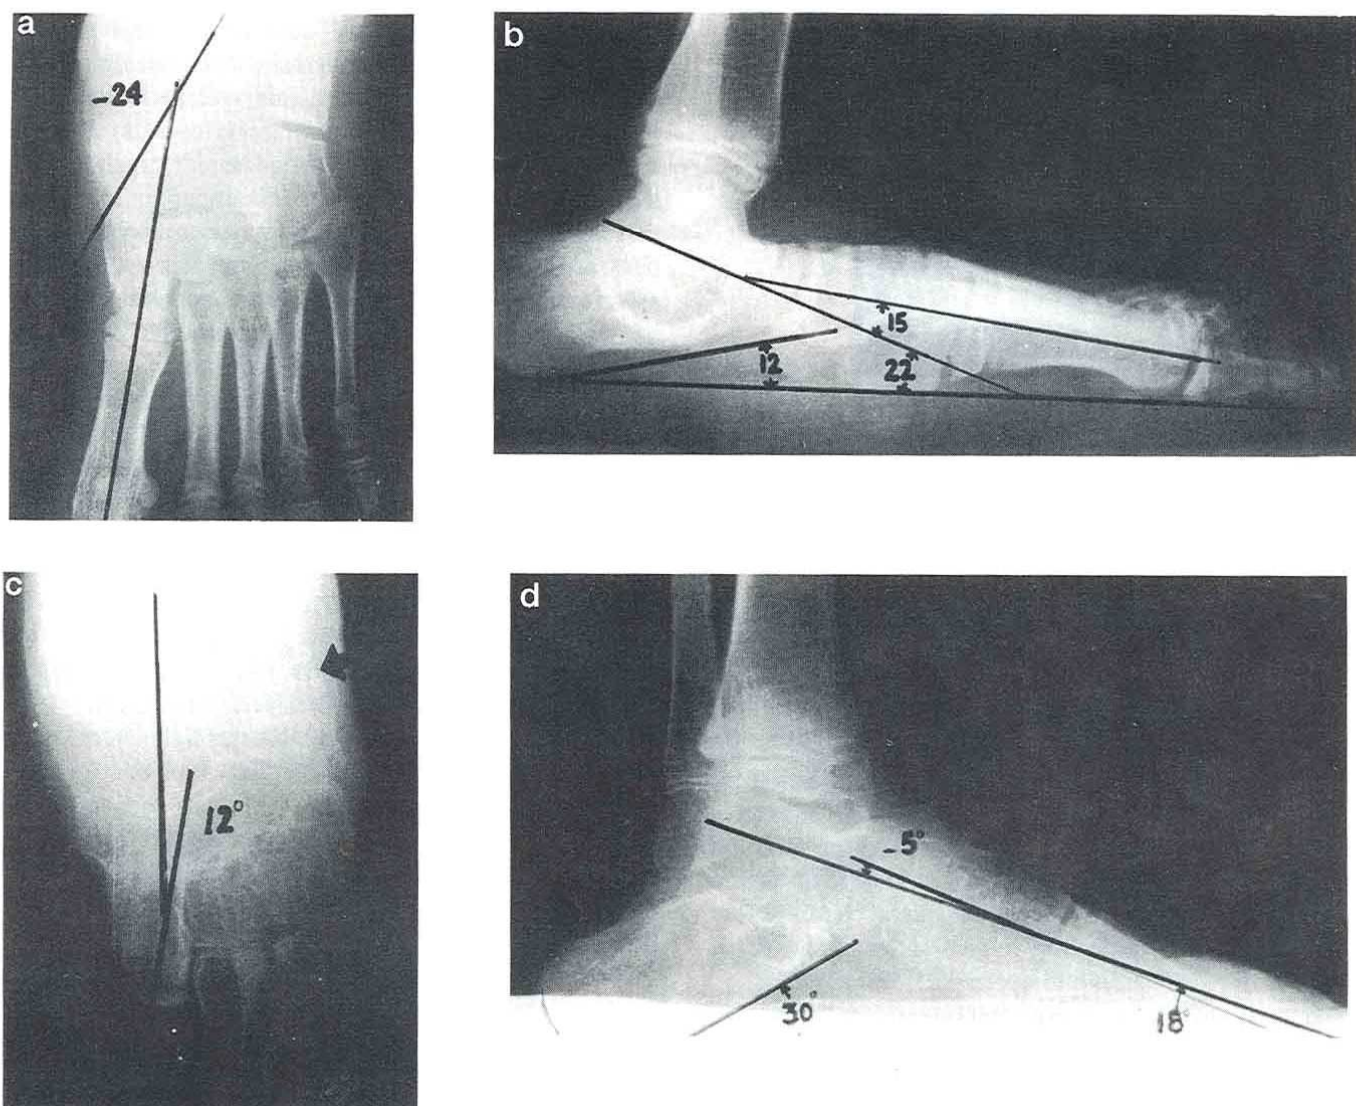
Improvement in radiological measurements. *a* and *b*, Preoperative standing radiographs with evidence of a resorbed iliac graft at site of an old Evans calcaneal osteotomy (case 4, left foot). The arch is flattened with naviculo-cuneiform sag and plantarflexed talus. *c* and *d*, Postoperative standing radiographs at 8 months with evident reconstruction of the arch, fusion of the naviculo-cuneiform articulation, and improvement in angle measurement.
